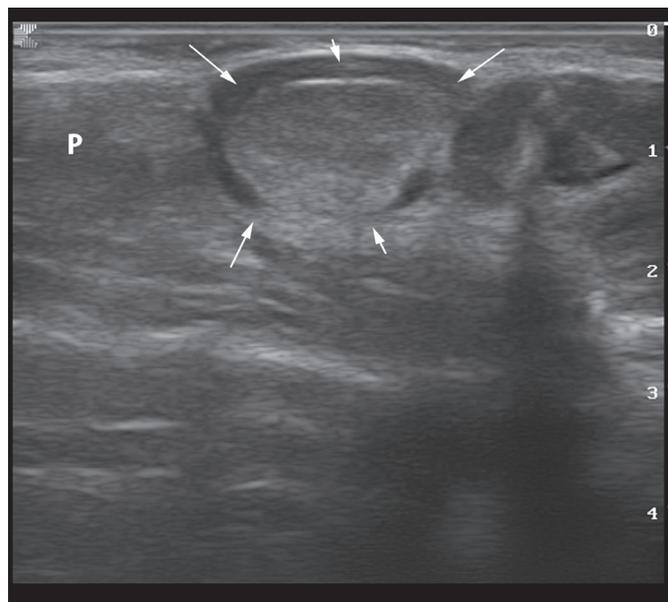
Transrectal ultrasonogram of the normal bulbourethral gland (arrows). P= pelvic portion of the urethra in a ram
